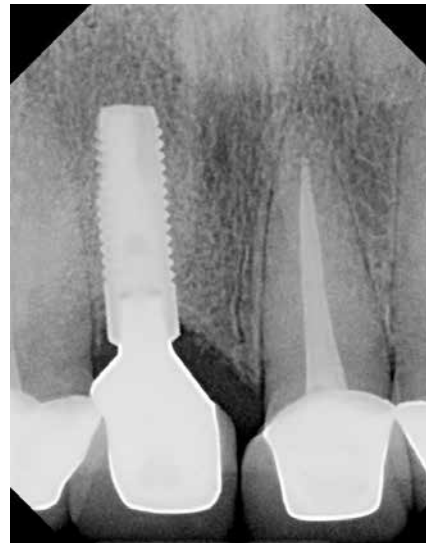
Periapical radiograph shows no signs of subgingival cement.
